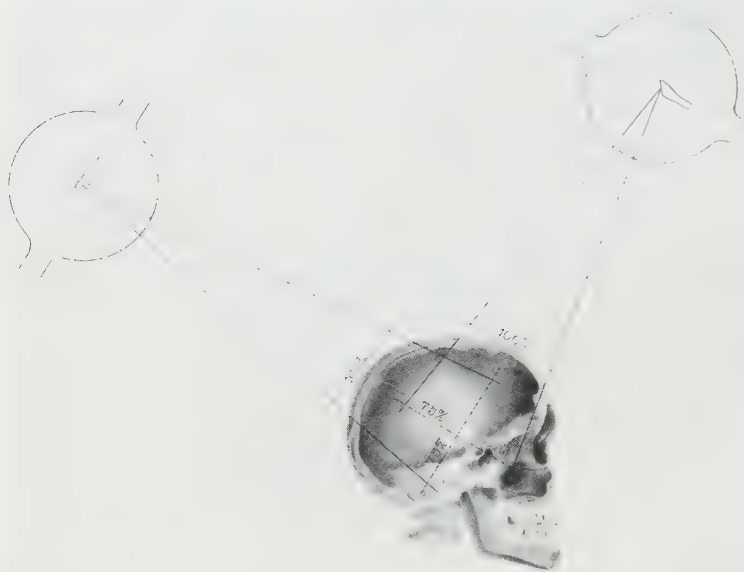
Great increase in the depth-dose obtained by delivering to the scalp a maximal dose (limit of tolerance), taken as 100 per cent, with roentgen rays generated at high voltage and with the roentgen tube at a distance from the scalp. If the distance between the cerebral tumor and the scalp is only one-fourth the total distance between the tumor and the target of the tube, 75 per cent of the 100 per cent delivered to the scalp will be obtained at the level of the tumor. By treating through four or six fields the tumor can be made to receive a total dose of from 300 to 450 per cent. An equivalent or even greater depth-dose can be obtained with radium, but this requires a large quantity of radium and prolonged exposure, and the cost is greatly increased.
